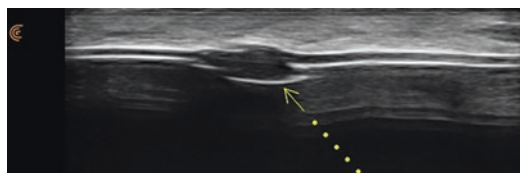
Grayscale ultrasound image of smooth saline filled breast implant. Arrow shows the filling valve on the anterior surface of the implant
